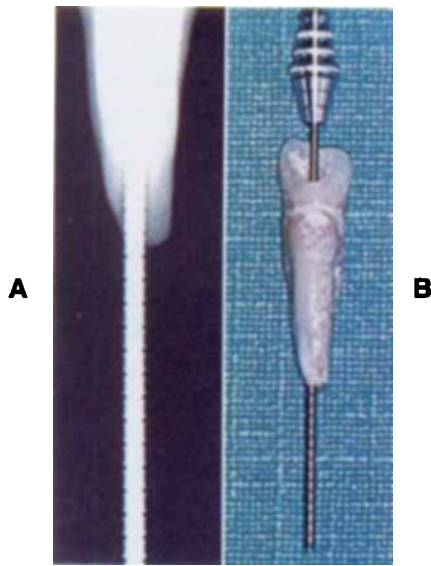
■ Radiograph (A) of millimeter measuring rod passing through apex (B).
